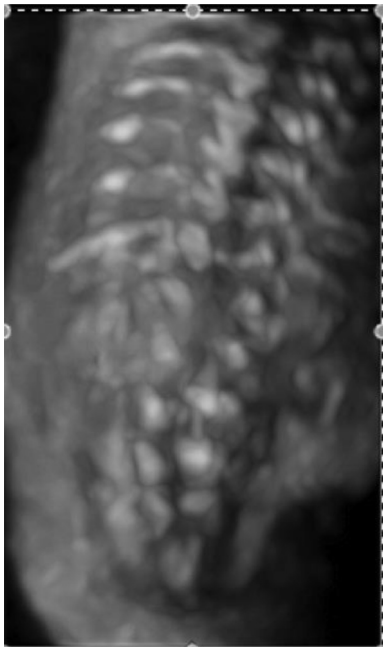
Ultrasound image of fetal spine in sacral agenesis.
